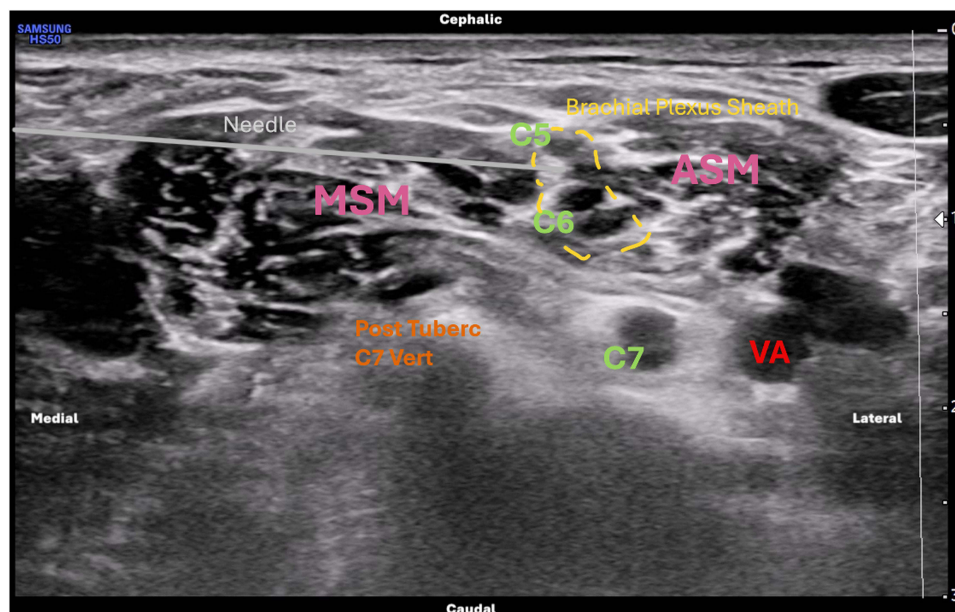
Ultrasound-guided InF approach for ISBPB: the needle tip placement is within the brachial plexus sheath between C5 and C6 nerve roots (yellow dashed lines). Abbreviations: MSM, Middle Scalene Muscle; ASM, Anterior Scalene Muscle; VA, Vertebral Artery; Post Tuberc C7 Vert, Posterior Tubercle of C7 Vertebra.
